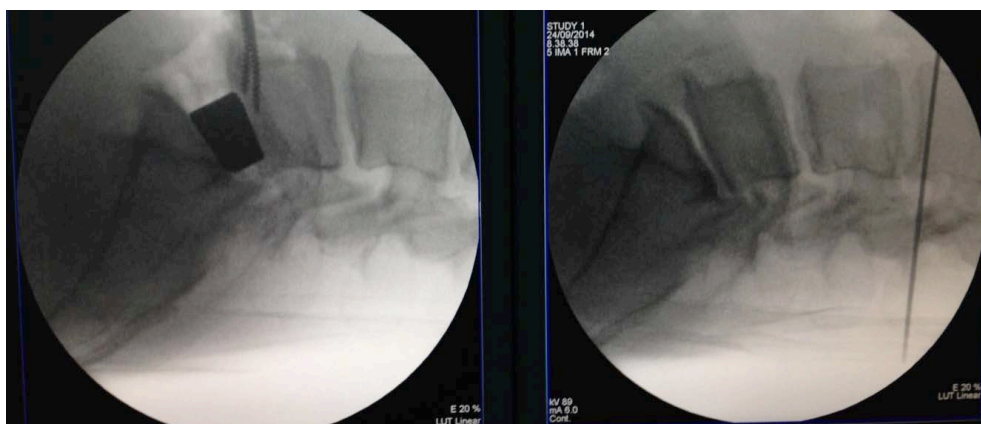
Intraoperative X-ray showing the increase of lumbar lordosis after cage implant.
